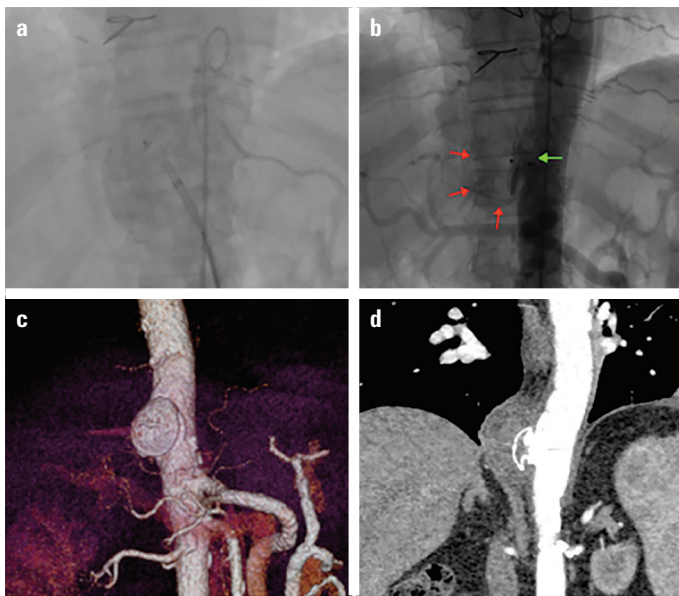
(a) The occluder device is inside the aneurysm, and the distal disk released and ready for positioning. (b) The distal disk of the septal occluder device was deployed into the APA sac (red arrows show the margin of the sac), the body of the occluder was placed in the neck of the APA, and the proximal disk (green arrow) was deployed on the aortic side. (c) 3-D view of occluder device after the procedure on multidetector computed tomography of the thorax and abdomen. (d) Multidetector computed tomography of the thorax and abdomen revealed optimal positioning of the occluder device and no leakage into the sac
